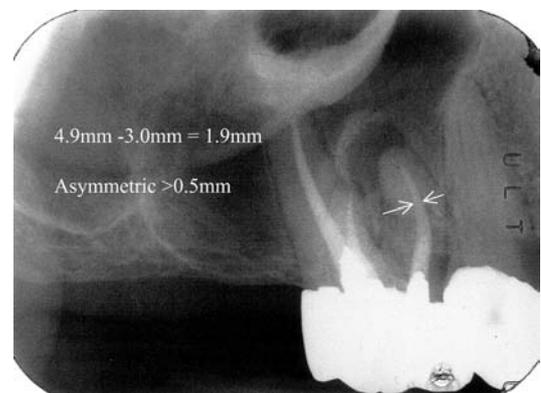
Periapical radiograph, demonstrating obturating material not centered within the mesial buccal root of tooth #3. Horizontal measurements from periodontal ligament to the gutta-percha differ by 1.9 mm. Asymmetric study criteria was a difference of at least 0.5 mm.
